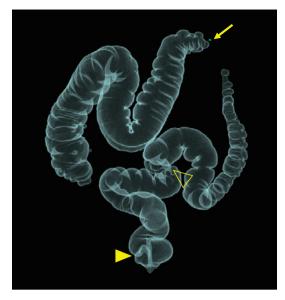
A computed tomography colonography after colonoscopy, showing the locations of the three lesions. Two early colon cancers were located at the splenic flexure (\rightarrow) and sigmoid colon (\triangle). The submucosal tumor was located at the lower rectum (\blacktriangle).
